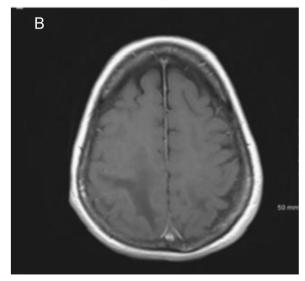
MRI of the brain. (A) FLAIR image shows extensive involvement of the posterior regions of both hemispheres sparing the gray matter and unassociated with mass effect. (B) T1WI with contrast showing bilateral signal hypointensities and no contrast enhancement.
